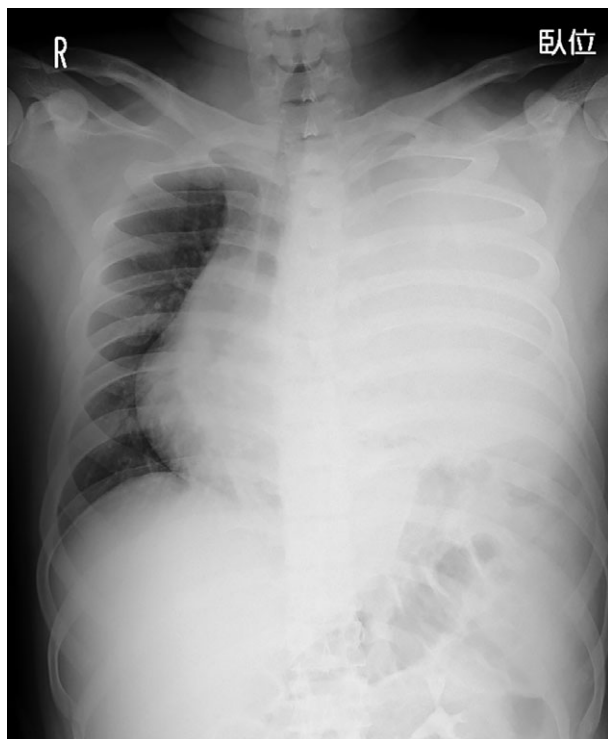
Chest X-ray shows diffuse consolidation of the whole left lung.
